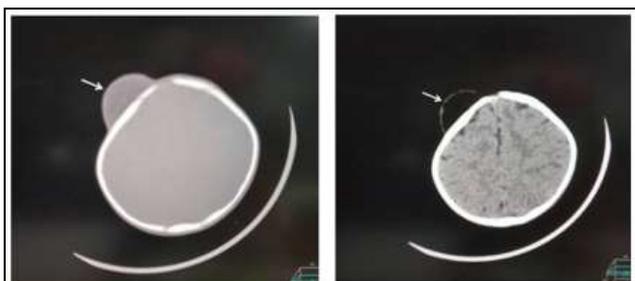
Plain CT Brain Axial Sections in Bone and Brain Window Show Well Defined Homogeneous Fat Attenuating Lesion (White Arrow) in the Scalp in Right Frontal Region - Lipoma
